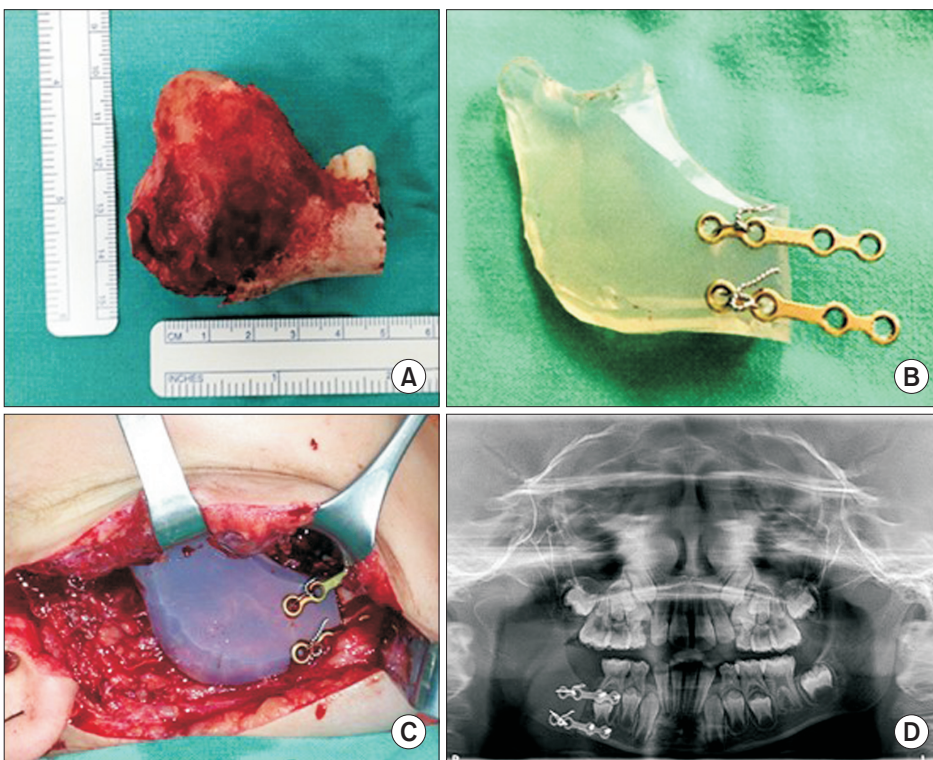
Right mandibular ramus osteoblastoma. A. Tumor. B. Silicon spacer for reconstruction of right mandibular ramus. C. Silicon spacer positioned and fixed in mandible. D. Immediate postoperative radiographic control by orthopantomography.
